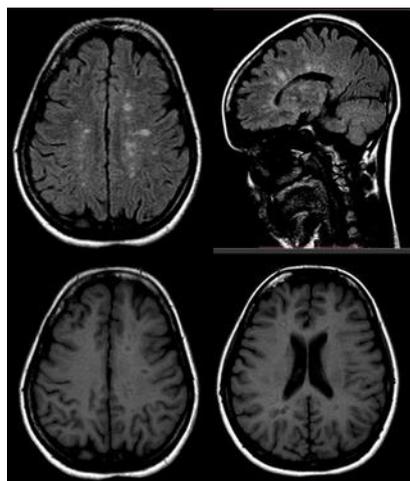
FLAIR and T1 weighted images depicting Dawson's fingers and T1 black holes respectively, in a patient with Multiple sclerosis
